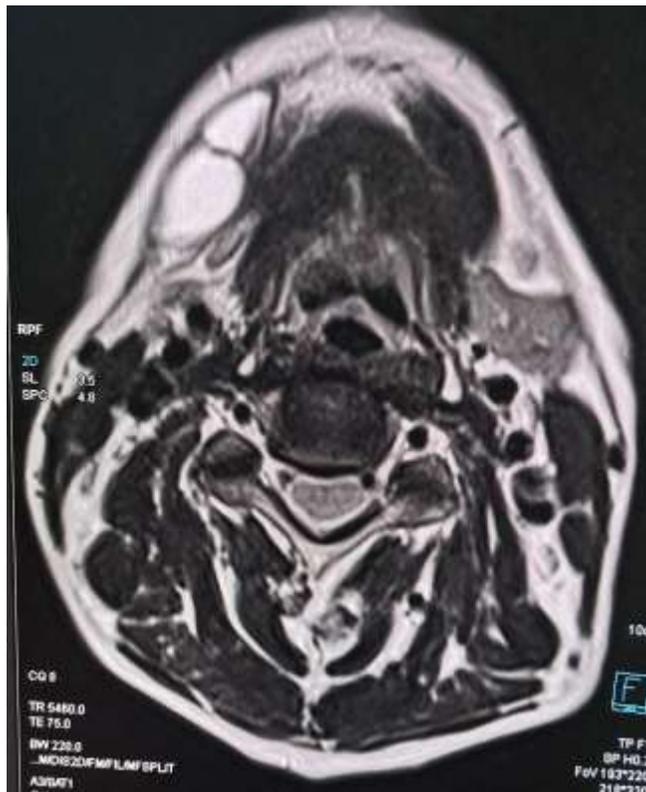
showing axial section of MRI
